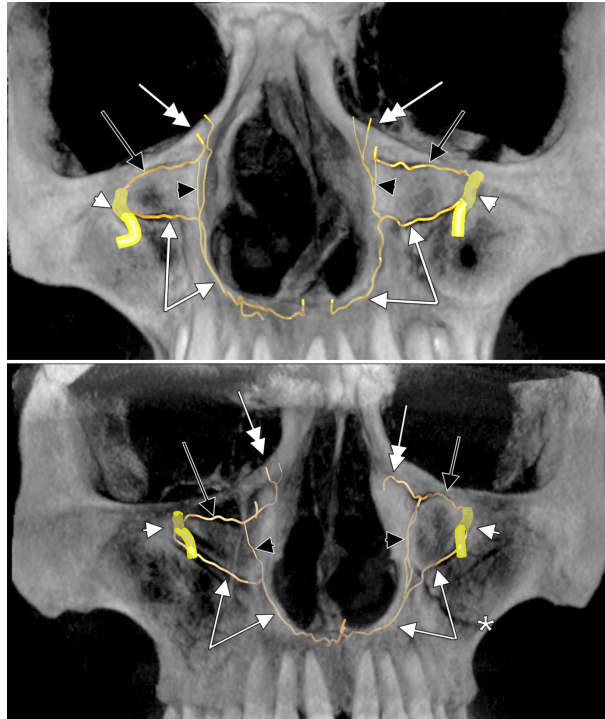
Three-dimensional volume renderizations of two different cases (adult female patient in the upper panel and adult male patient in the lower one), anterior view of the midface (Planmeca Romexis Viewer 3.5.0.R software, B&W X-Ray Filter). There are bilaterally indicated the infraorbital canal (white arrowheads), sinuous canal (white arrows), accessory infraorbital canal (black arrows), Parinaud's canals (black arrowheads) and the foramina of Macalister in the area of the notha suture (double-headed white arrows). The lateral antral canal (*) is indicated in the lower panel. B&W: Black & White.
